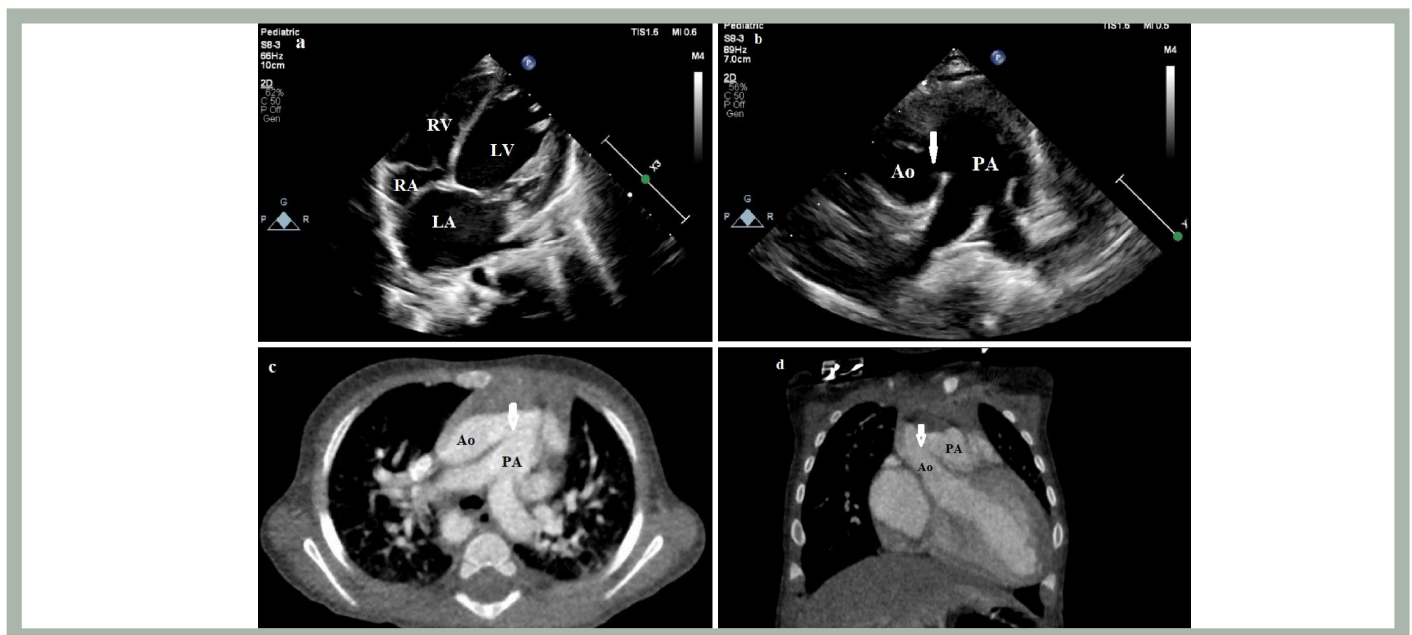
Echocardiography and computed tomography images of the patients with aortopulmonary window.
